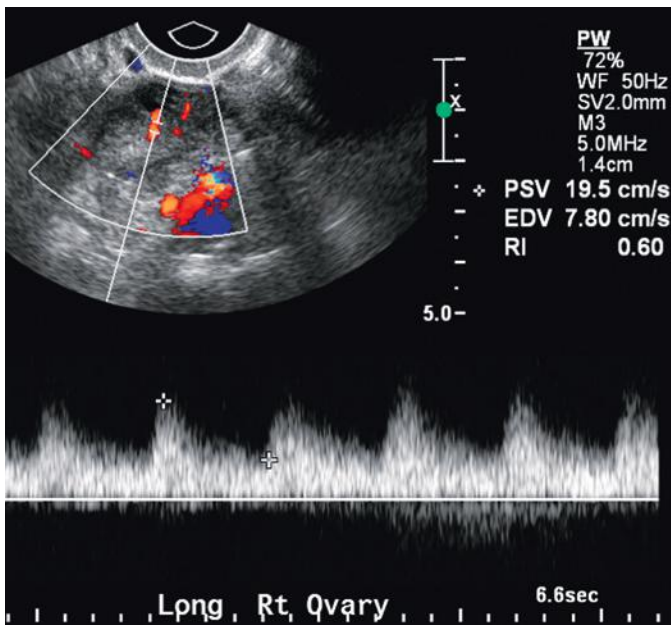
Ovarian artery. Spectral Doppler waveform from the right ovarian artery obtained just prior to ovulation reveals spectral broadening, slight rounding of the systolic peak, and pronounced diastolic flow consistent with a low-resistance waveform. The resistive index (RI) is 0.60.
